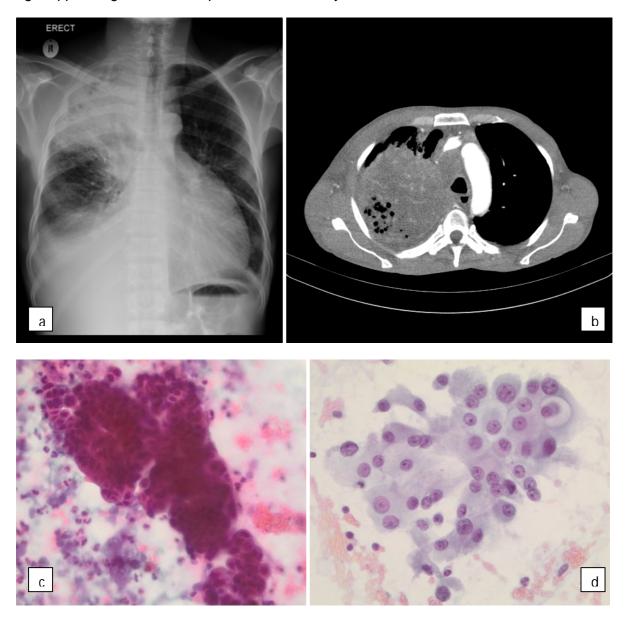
Large, right upper lobe mass with extensive lymphadenopathy on chest X-ray (a) and CT (b). Sputum - suspicious for malignancy. Large clusters of small, moulded, degenerate cells (c). FNA – Metastatic adenocarcinoma with giant cells, abundance of cytoplasm and prominent nucleoli, subclassified as pleomorphic carcinoma (d).
